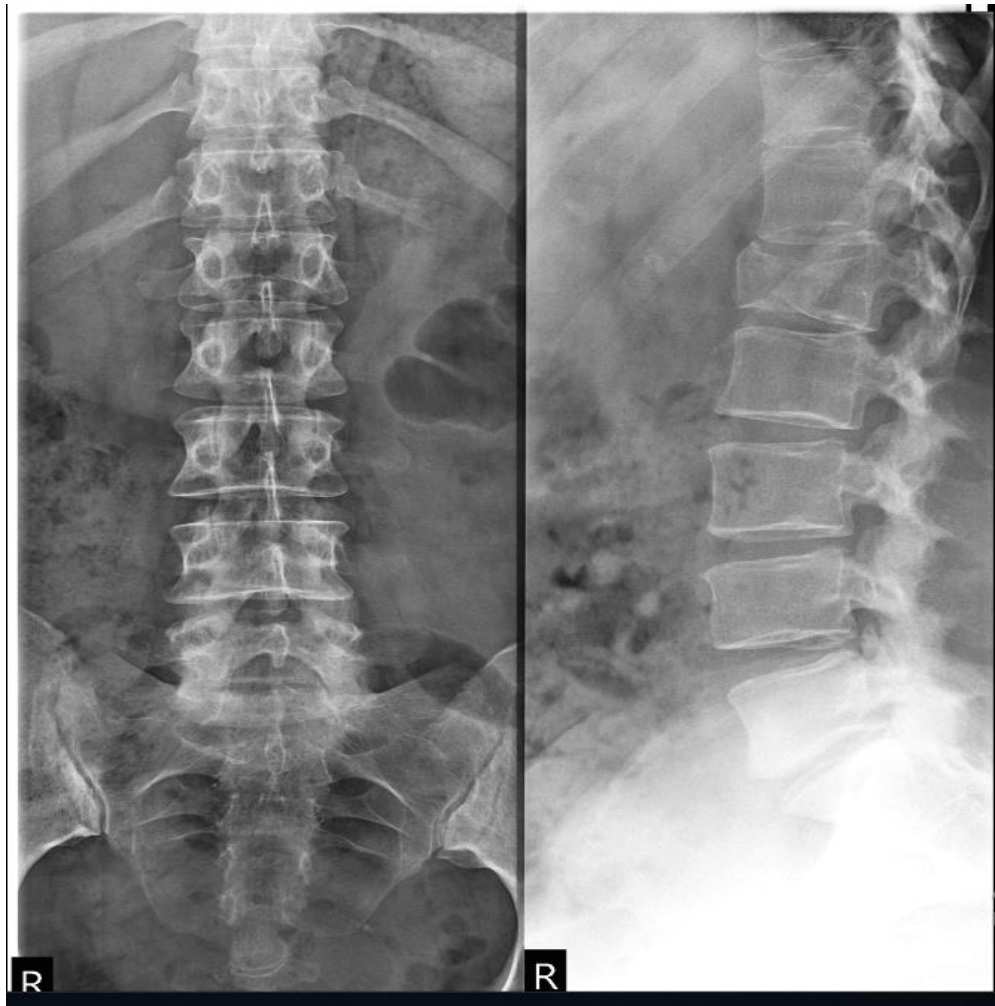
X-ray of the lumbar spine*
